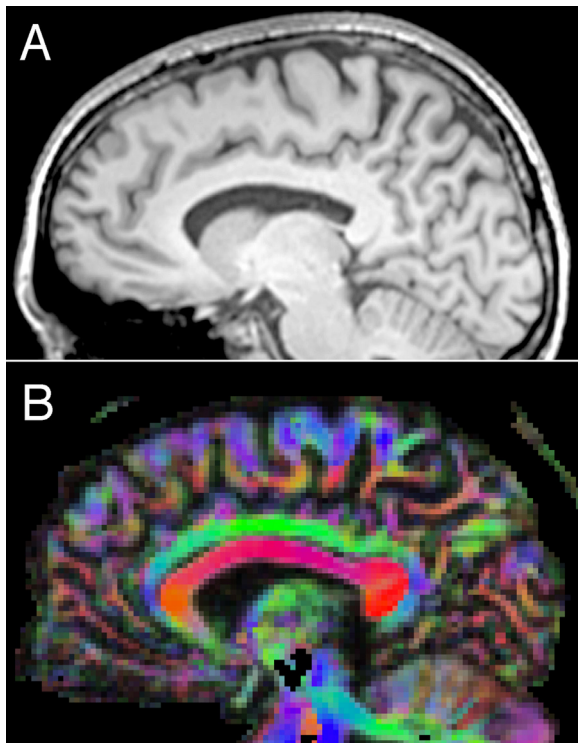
Examples of two types of magnetic resonance imaging-based structural images of the corpus callosum. (A) T1-weighted magnetic resonance imaging can be used to quantify cross-sectional area, volume, and morphology of the corpus callosum. (B) Diffusion magnetic resonance imaging can provide more detailed information about microstructural properties (e.g., white matter fiber orientation [indicated by different colors] and organization). (Images courtesy of Mike Tyszka, California Institute of Technology.)
